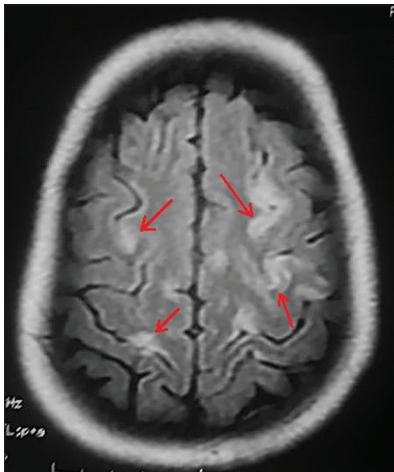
Cerebral MRI showing hyperintense cortical lesions at both frontoparietal regions (red arrows) in FLAIR, a quite uncommon finding in WE
